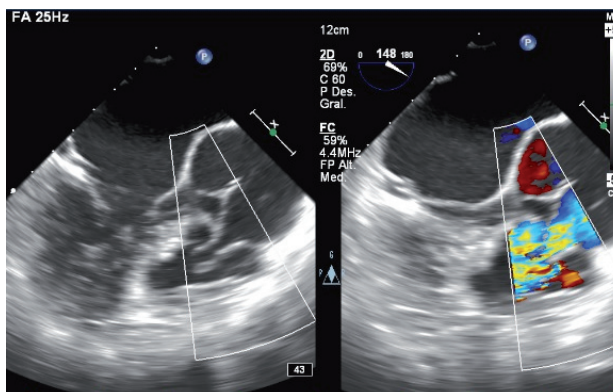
Transesophageal echocardiogram: 2D image of right Valsalva sinus fistulized to the right ventricle (left) and color Doppler (right) (see color image in the web).
